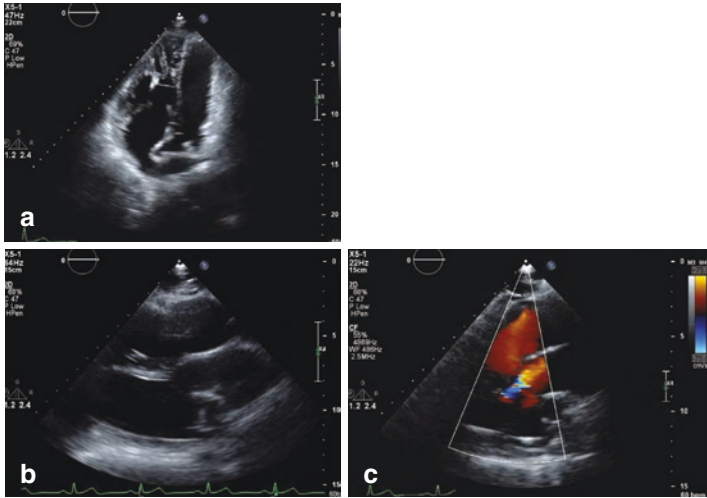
(a) Apical four-chamber view of patient with a Senning atrial switch after D-TGA, with large, hypertrophied RV, small sub-pulmonic LV, atrial baffle (b) parasternal long view of the aorta originating from the RV, superior and parallel to the pulmonary artery, which originates from the LV, and (c) with color Doppler
